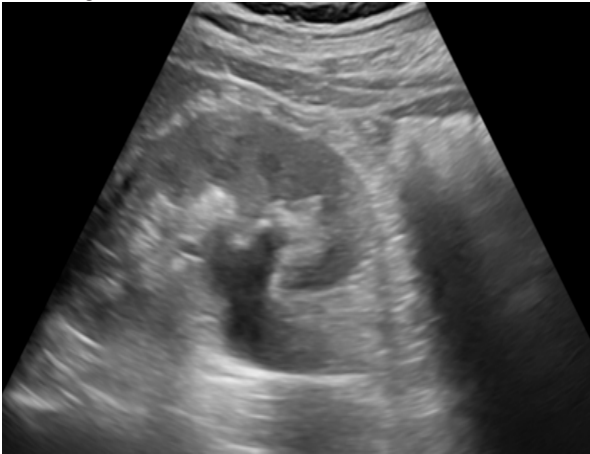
Grey scale ultrasound demonstrating dilated pelvicalyceal system of left kidney (obstructed kidney)
